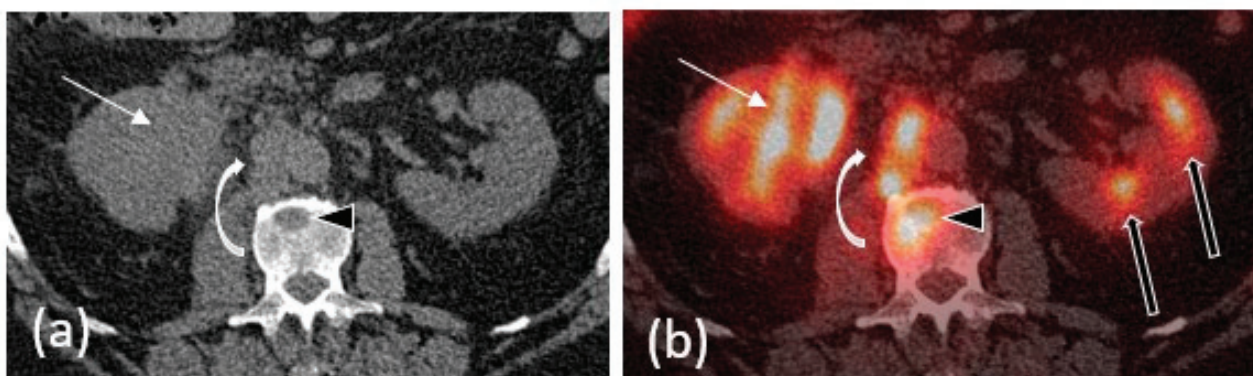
A 63-year-old male with metastatic UTUC. (a) Non-contrast CT images demonstrate an infiltrative right renal mass (white arrow) with obliteration of the renal pelvis. (b) Fusion PET/CT images demonstrate intense FDG uptake in the mass. FDG avid retroperitoneal lymph node metastases (curved white arrow) and osseous metastases (black arrowhead) are also included in this image. Note the physiologic radiotracer activity in the left renal collecting system (black arrows).
